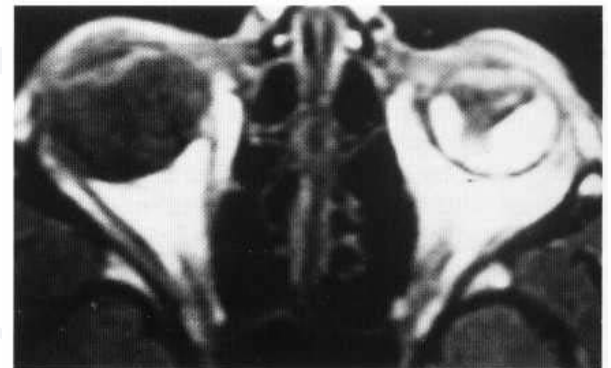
Haemorrhagic retinal detachment. T_1 -weighted MR image demonstrates elevation of retina by hyperintense haemorrhage. Retinal attachment anteriorly to the *ora serrata* and posteriorly to the macula creates a characteristic V-shaped configuration.
